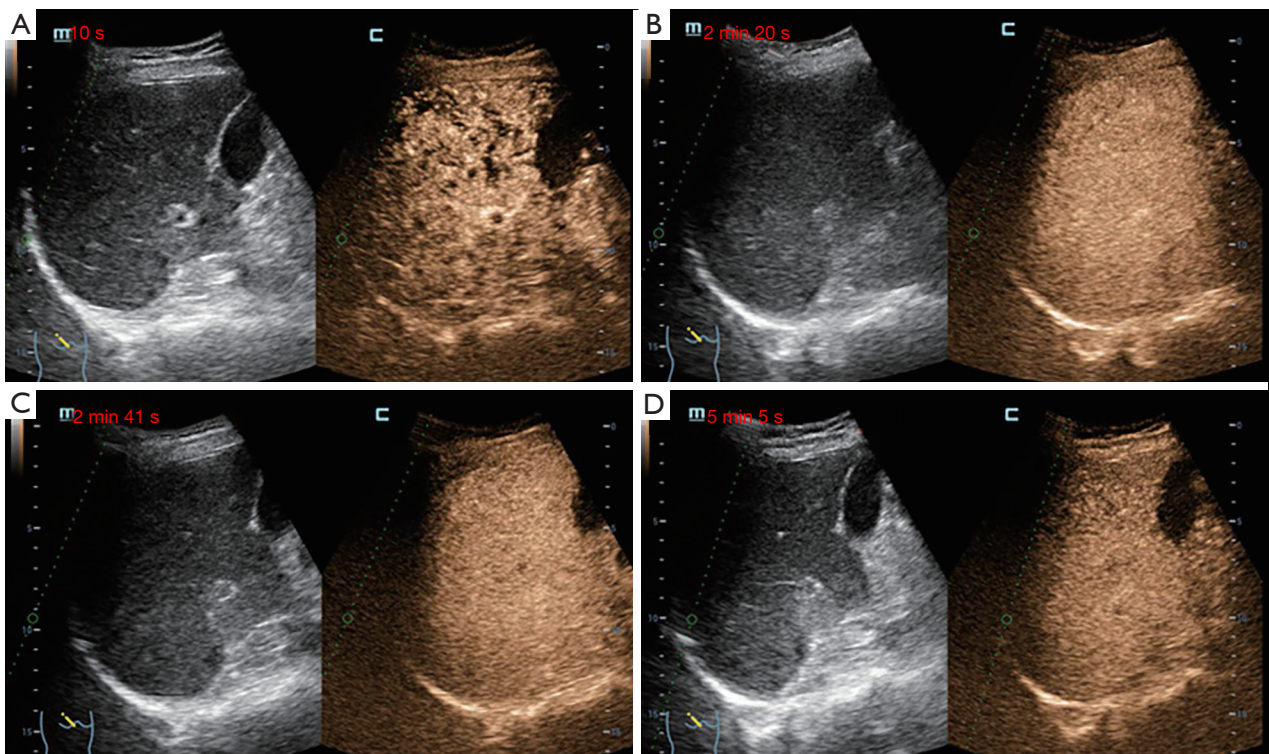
Contrast-enhanced ultrasound. (A) The arterial phase; (B) the portal phase; (C) the delayed phase; (D) 5 minutes later.
